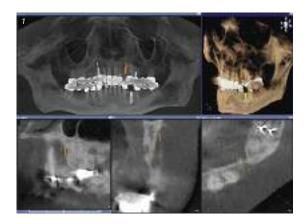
Preoperative CBCT scan to evaluate the horizontal and vertical bone supply (Galileos, Sirona Dental Systems).
